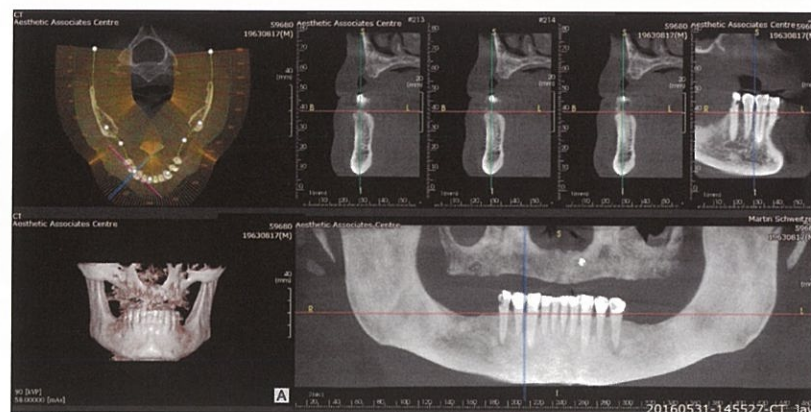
CBCT scan from consult.
